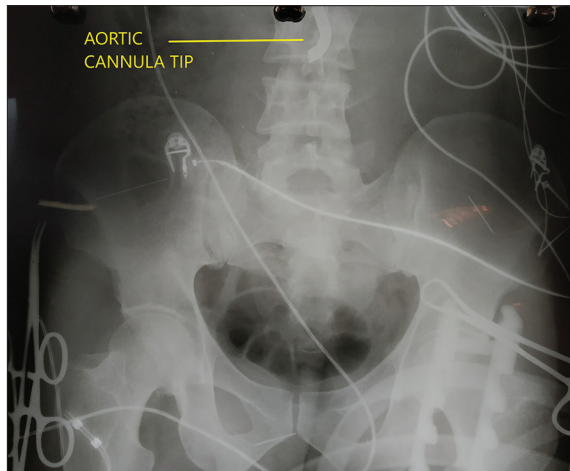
Abdominal X-ray showing dislodged aortic cannula tip at the level of third lumbar vertebra
